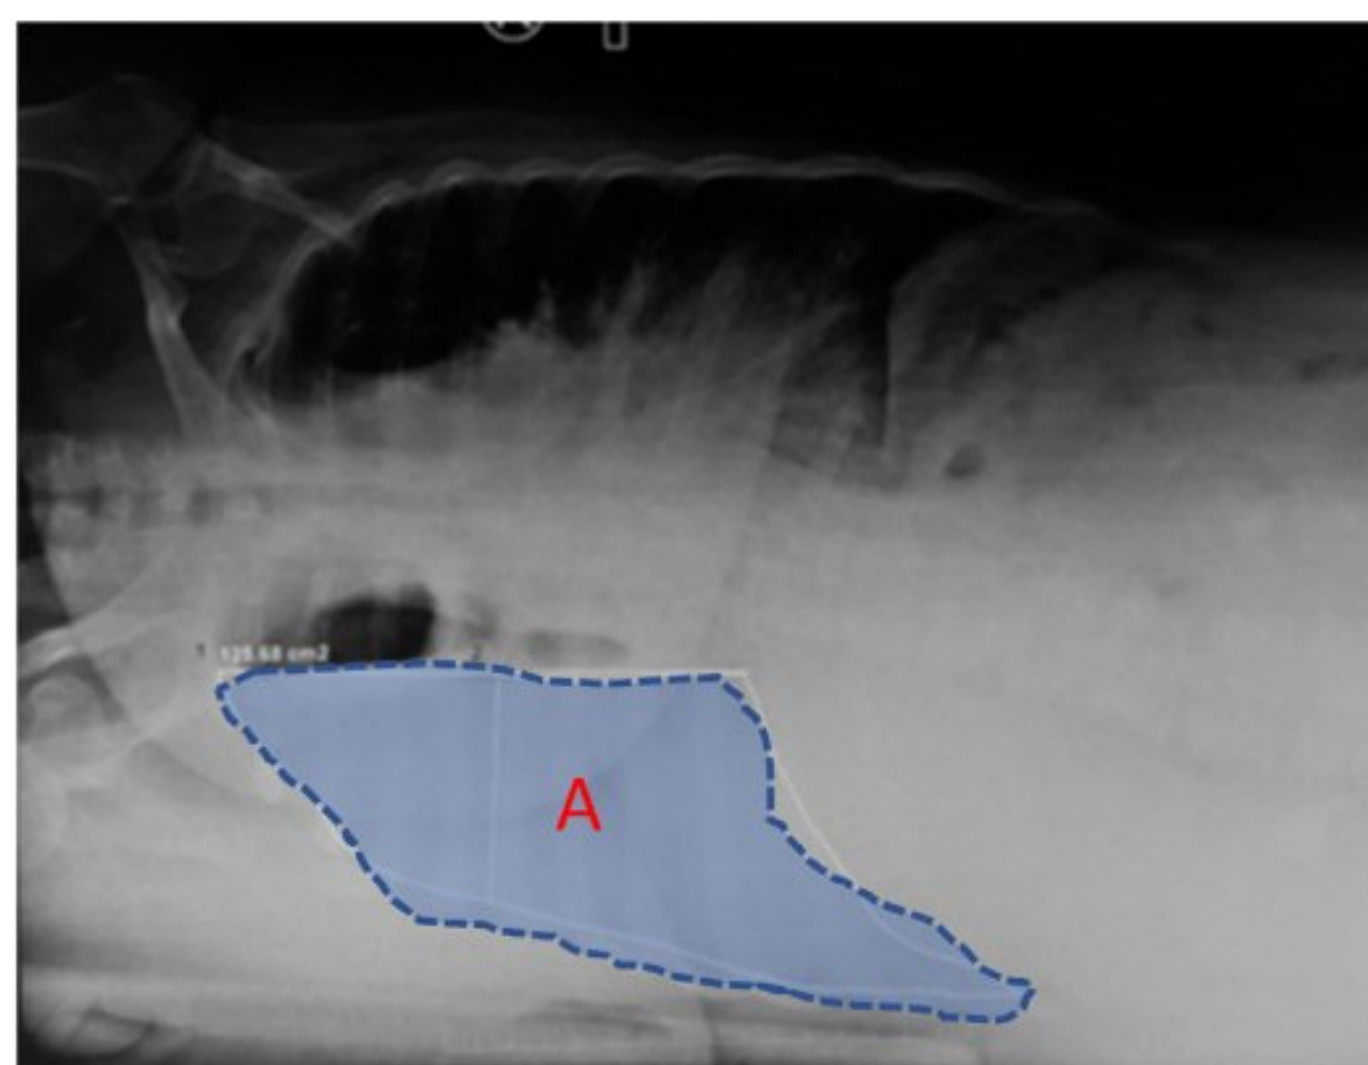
Area measurement of image of pleural effusion (A) of lateral decubitus position of chest x-ray.
